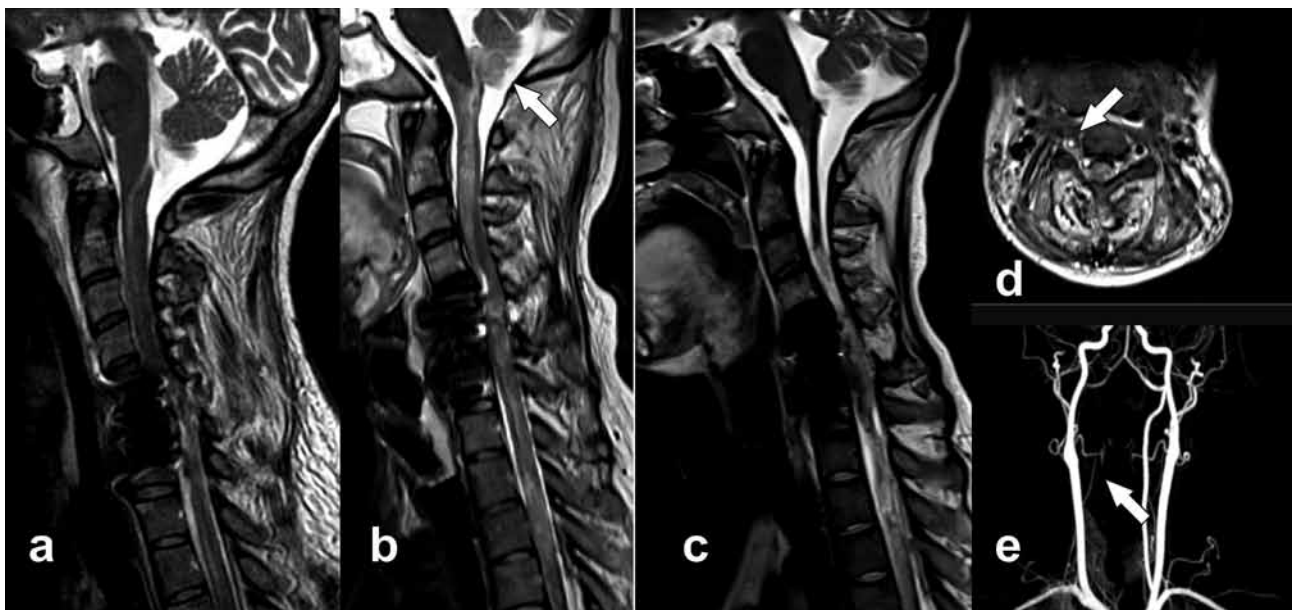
MRI shows a traumatic lesion in the cervical spine (a). Twenty days later, a mass in posterior fossa was evident (b). This mass disappeared after 6 months (c). Vertebral artery obstruction (d, e).
